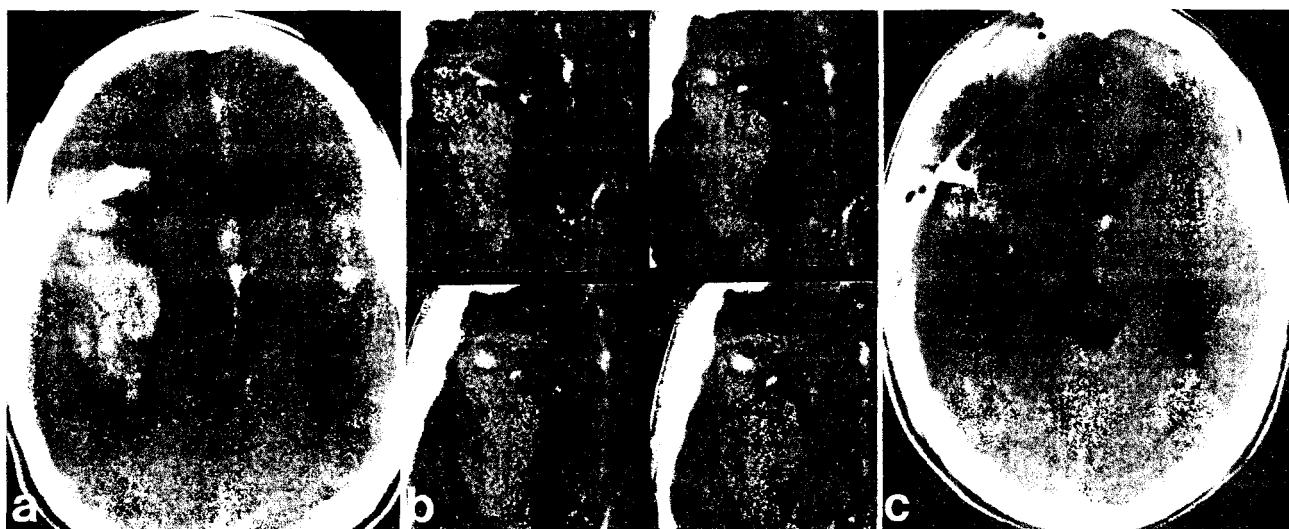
Case 3. a, Preoperative CT scan showing a large right frontotemporal intracerebral hemorrhage. b, Infusion CT scan demonstrating a small aneurysm of the right middle cerebral artery (arrow) and the M1 segment (arrowheads). c, Postoperative CT scan revealing extensive right hemisphere infarction.
